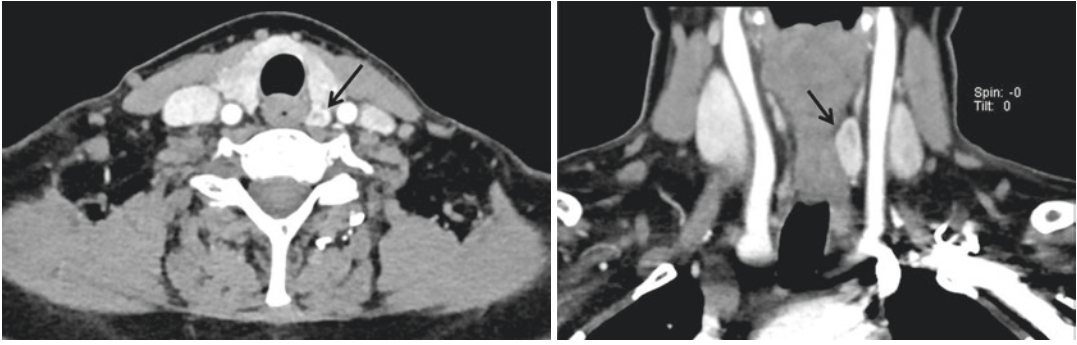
Parathyroid adenoma in a 40 years old man patient diagnosed as MEN type 1. On transverse and coronal-reformatted CT images, a heterogeneously enhancing solid nodule (arrows) is seen in the left retrothyroid region
